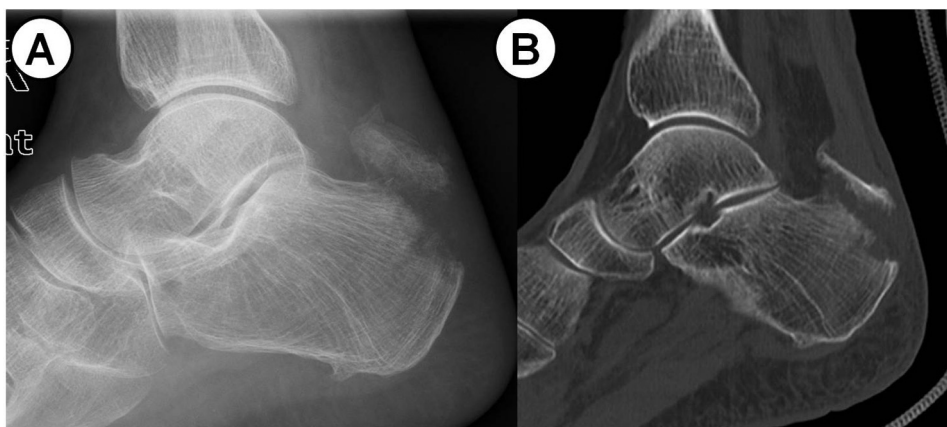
(A) Preoperative radiograph shows a displaced avulsion fragment of the calcaneal tuberosity. (B) Preoperative CT scan shows a limited bone stock with a shell of thin cortical bone.
